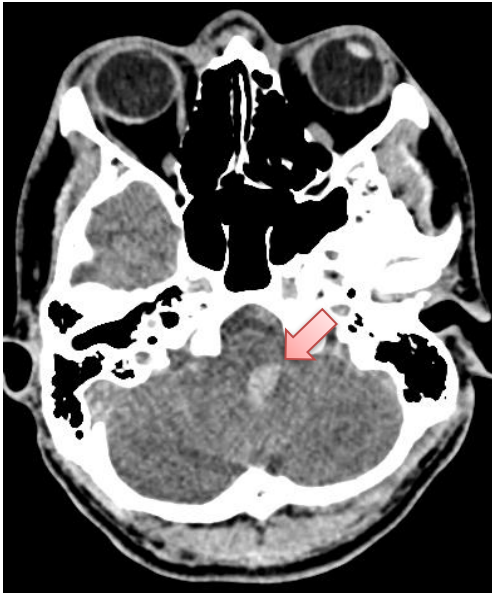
CT scan of the head showing hemorrhagic medulla oblongata
